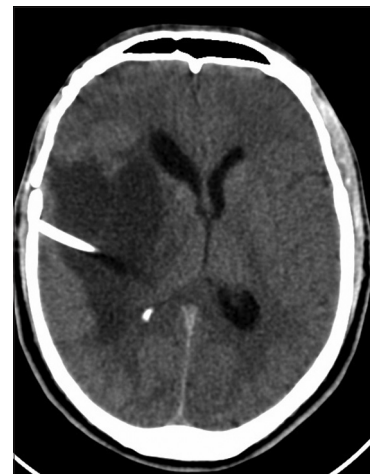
Axial CT Brain showing Interval insertion of the right-sided ventriculoperitoneal shunt with mild interval improvement in the hydrocephalus and midline shift Stable amount of surrounding vasogenic edema with decrease in the size of cystic
